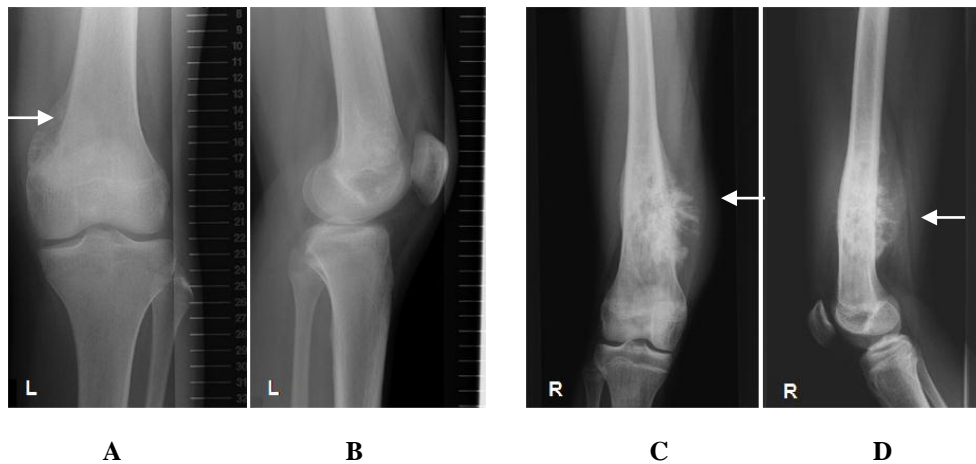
Typical radiographic appearance of OS. Anteroposterior (A) and lateral (B) radiograph of the left distal femur show a typical “Codman’s triangle” (arrow) in an OS patient. A “sunburst”-type periosteal reaction (arrows) can be seen in the anteroposterior (C) and lateral (D) radiograph of the right distal femur of an OS patient.
